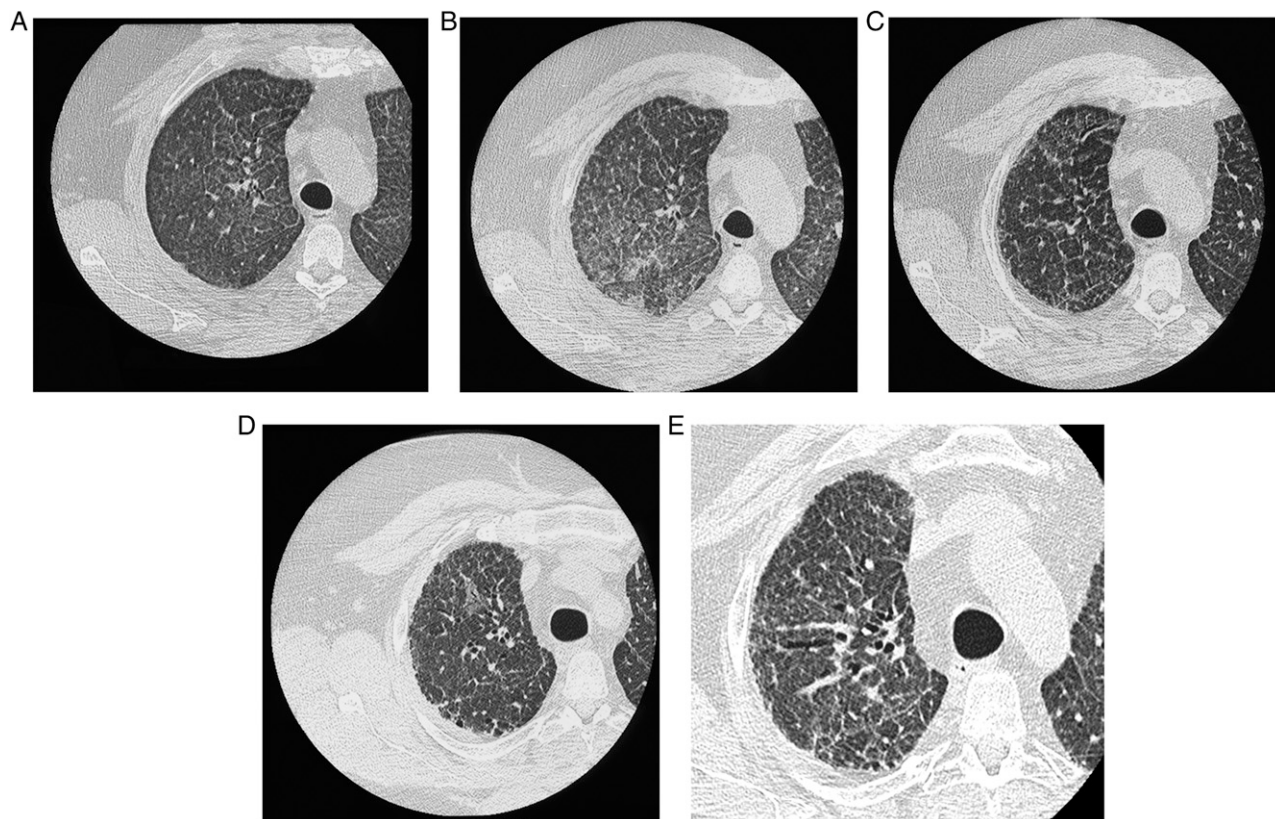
Case A: CT scans of the chest showing progression of disease over 5 years. A, In January 2001 at age 51 years, 3.5 months after leaving employment. In this area of the lung, the predominant finding is mild interlobular septal thickening. B, In July 2001 at age 51 years, 10 months after leaving employment. Increased septal thickening and the development of ground-glass opacities are seen. C, In February 2002 at age 52 years, 1.5 years after leaving employment and 6 months after whole-lung lavage. Fibrotic changes are now apparent, including subpleural septal thickening and traction bronchiectasis. D, In June 2005 at age 55 years, nearly 5 years after leaving employment. Early honeycombing changes are apparent posteriorly. E, In July 2006 at age 56 years, nearly 6 years after leaving employment. Further increases in septal thickening, traction bronchiectasis, and subpleural fibrosis have occurred.
